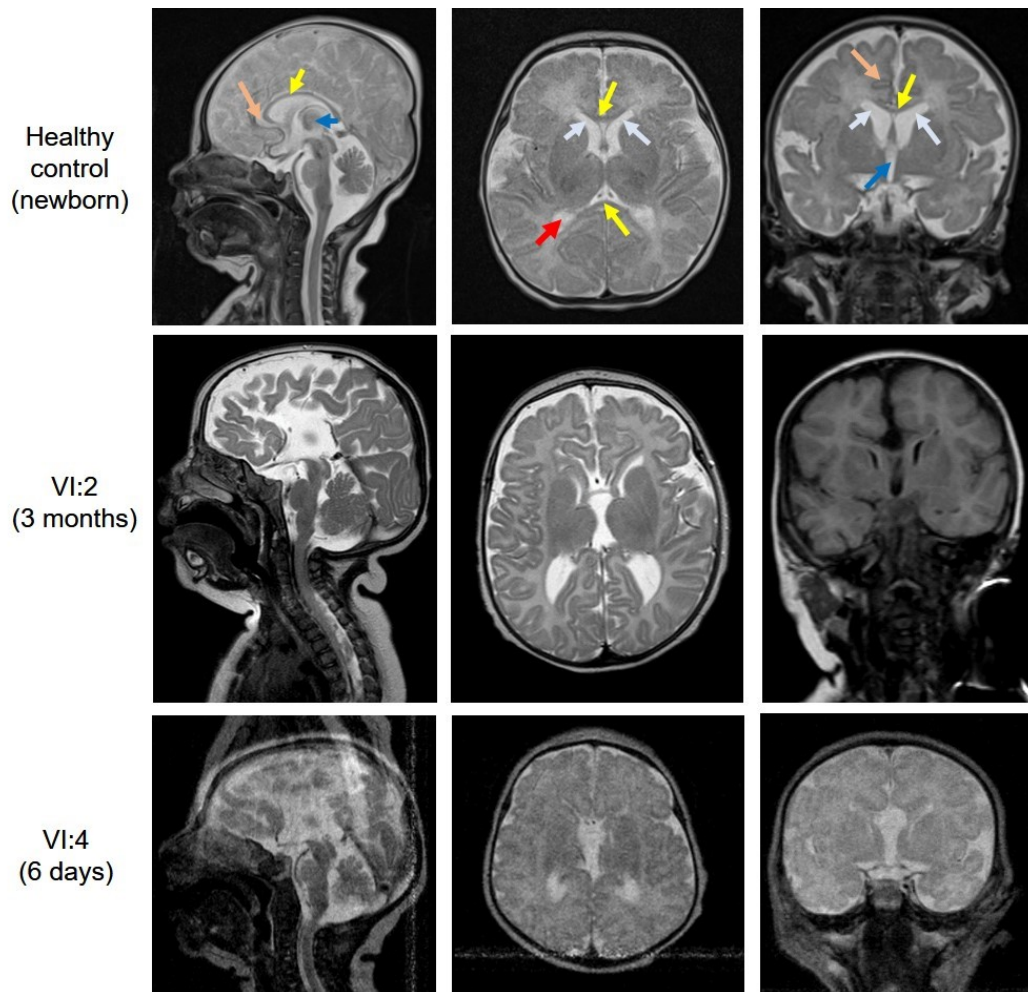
MRI pictures of the 2 patients and a healthy control. Sagittal, axial and coronal cross sections of the brain were selected (left to right). Yellow arrows indicate the corpus callosum, which is absent in the two patients. The gyrus cingula is hypoplastic (light red), the third ventricle is dilated and reaches cranial (dark blue arrow) in both patients. Frontal horns (lateral ventricles; light blue arrow) are deformed in VI:2 while the occipital (posterior) horns (red arrow) are enlarged in both patients.
